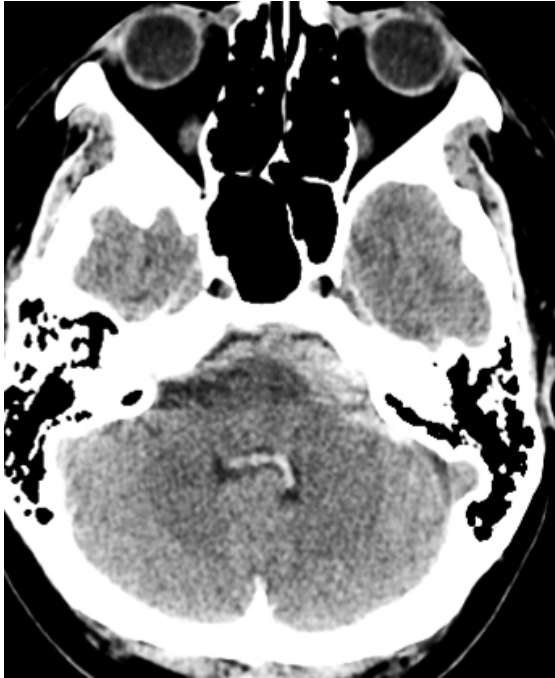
Axial CT scan: subarachnoid hemorrhage of posterior cranial fossa and in the fourth ventricle
